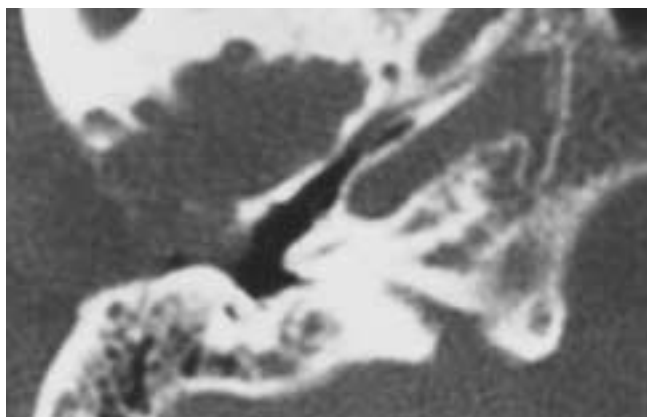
Benign giant cell tumor. Axial CT. Tumor partially occludes the EAC. Well-defined scalloped borders suggest a benign lesion.
